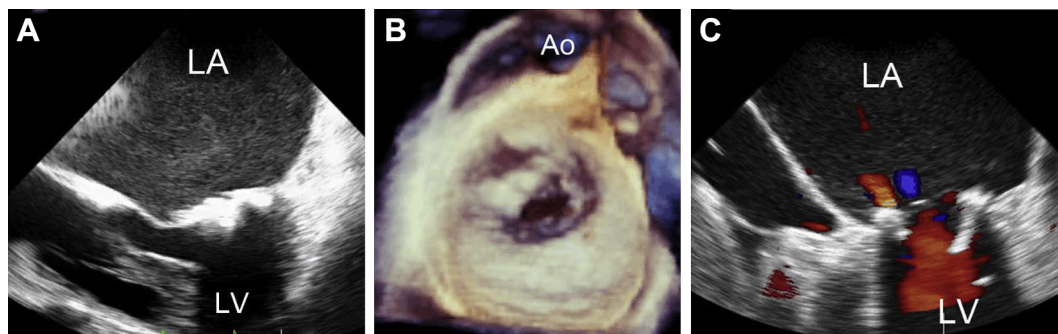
(A) Two-dimensional (2D) transesophageal echocardiography (TEE) (apical 4-chamber view) in a patient with rheumatic mitral stenosis shows fusion of commissures and vegetation formation; (B) fish mouth shape of mitral valve orifice is delineated by 3D TEE enface LA view; and (C) mitral stenosis is replaced by prosthetic tissue mitral valve. Ao = aorta; LA = left atrium; LV = left ventricle.
